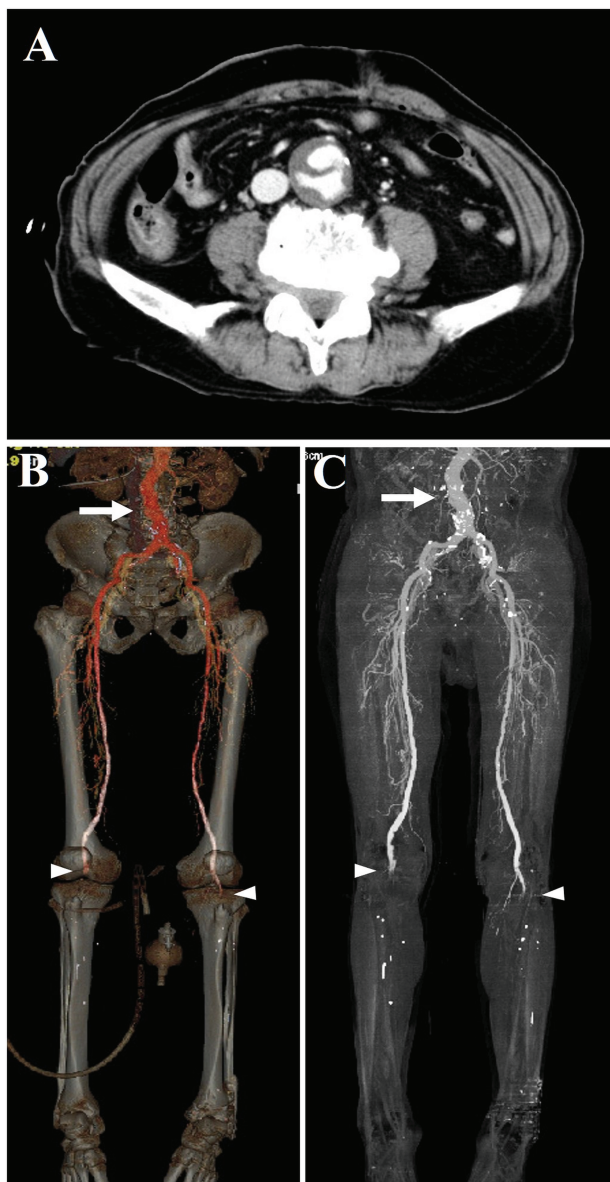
(A) Contrast-enhanced computed tomography showing AAA with mural thrombi just above the iliac bifurcation. (B and C) Occluded popliteal arteries on both sides (arrowheads). Arrows indicate AAA, a possible embolic source.
